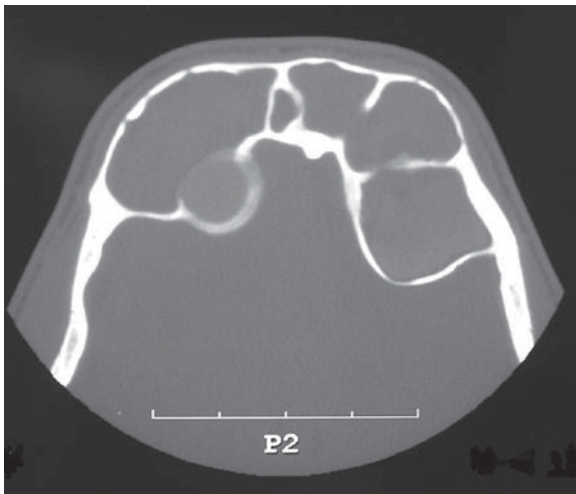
Axial noncontrast CT image of the frontal region in bone windows. There has been expansion of bilateral frontal sinuses with extension of supraorbital ethmoid cells intracranially. Note that the hyperdense sinus contents are not seen in this image. This patient had AFS
